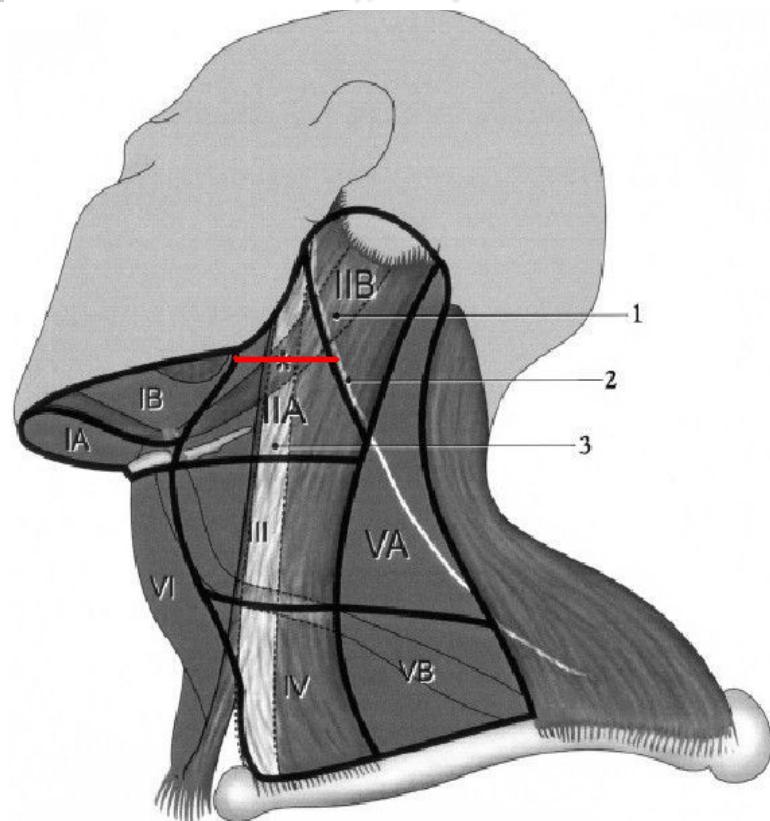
Neck nodal levels (after Robbins *et al.* [19]). Asterisk denotes crossing of jugular vein by posterior belly of digastric muscle, marking cranial-most CT image at which Level II nodal CTV delineated in contralateral side of neck. It excluded uppermost part of sublevel IIA and most of IIB. 1, posterior belly of digastric muscle; 2, spinal accessory nerve; 3, internal jugular vein.
